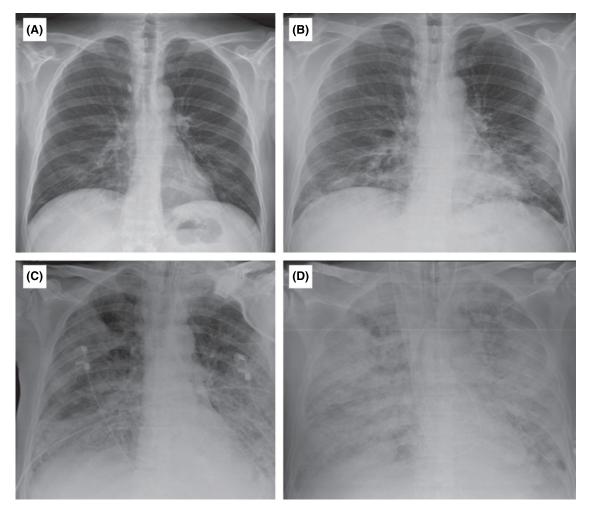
ARDS chest radiograph changes over the course of 7 days. (A) No pathologic changes. (B) Bilateral pulmonary infiltrates in lower lobes. (C) Significant bilateral consolidation with notable air bronchograms. (D) Severe opacification of right and left lung ("white-out"). Reproduced with permission of the © ERS 2018. European Respiratory Review, Dec 2014:23(134):519–530. doi:10.1183/09059180.00001314.
